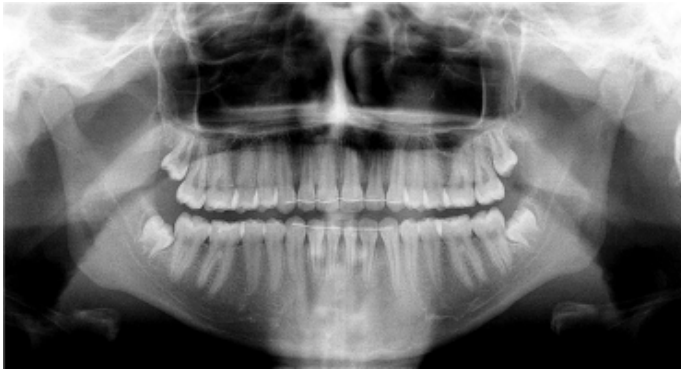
Showing bone healing occurred within 5 months on panoramic radiography.
